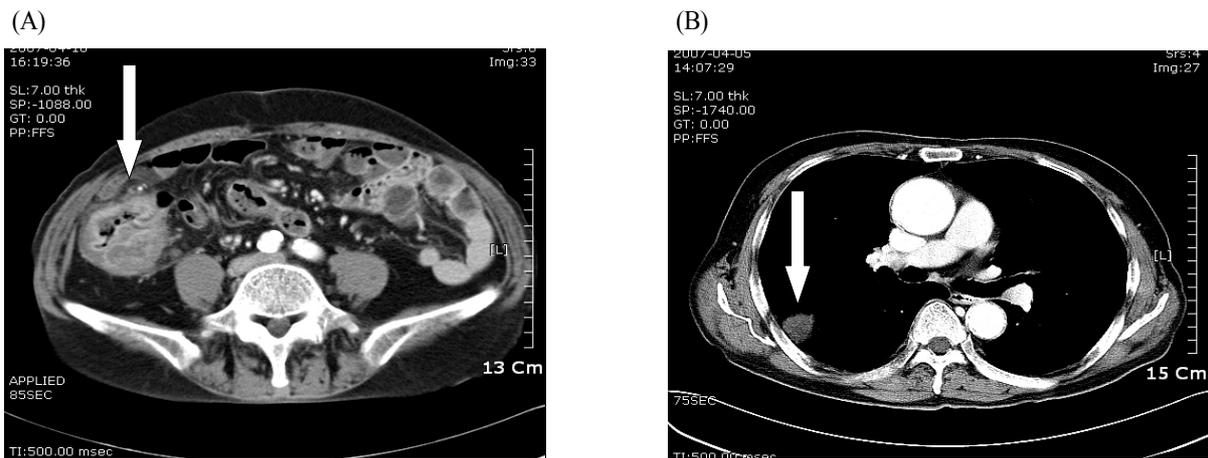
Abdominal CT scan showed wall thickening of the ascending colon (A). Chest CT scan showed metastatic nodule in the right lower lung field (B).
